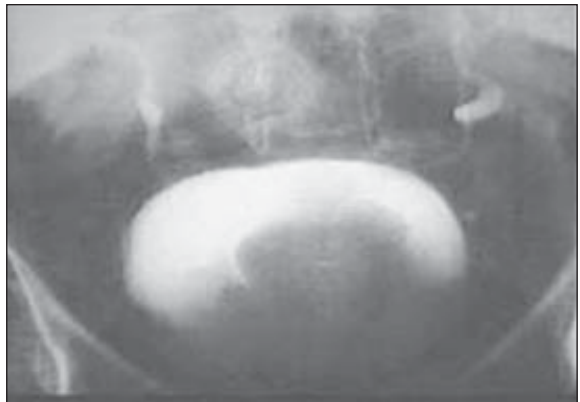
X-ray diagnosis of the BPH. Cystogram. A defect in filling up due to internal bladder component
